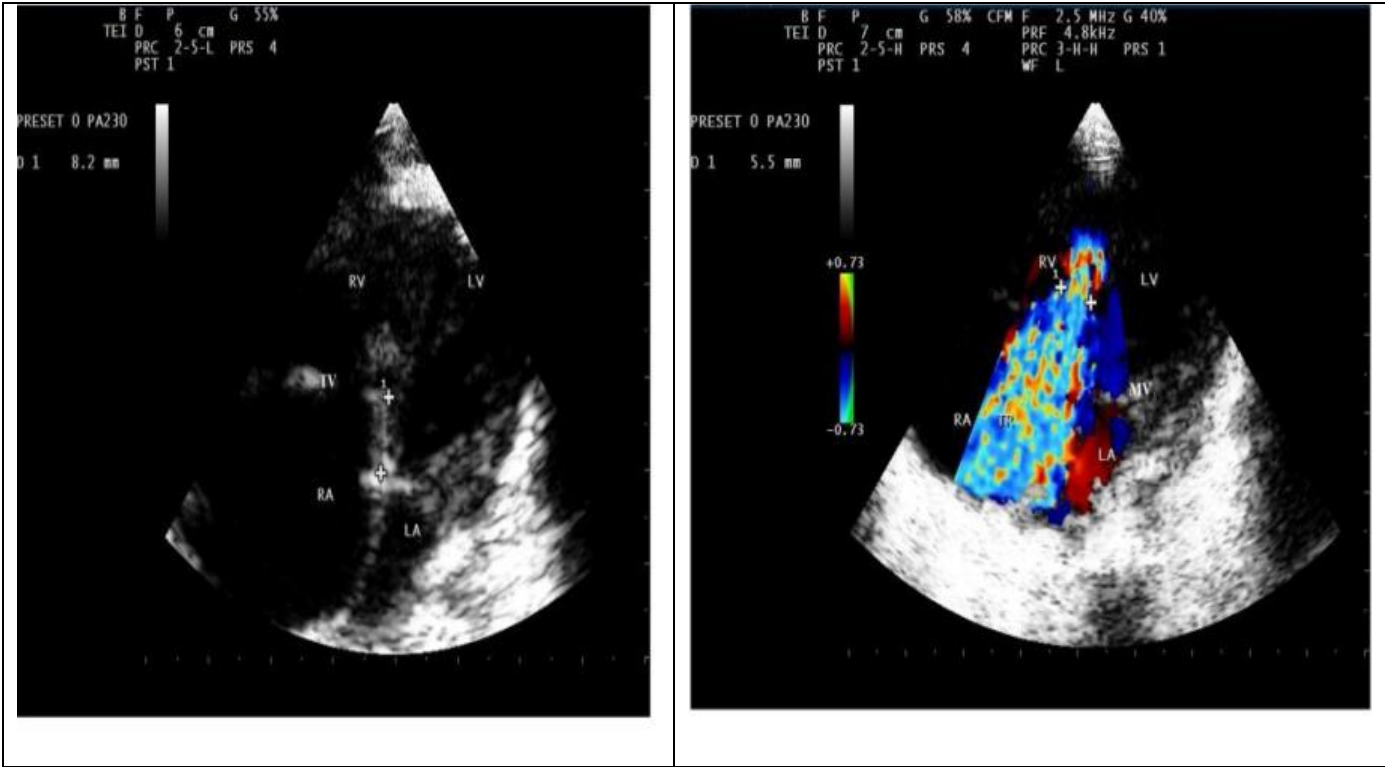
echocardiographic finding (ASD, VSD, TR)
